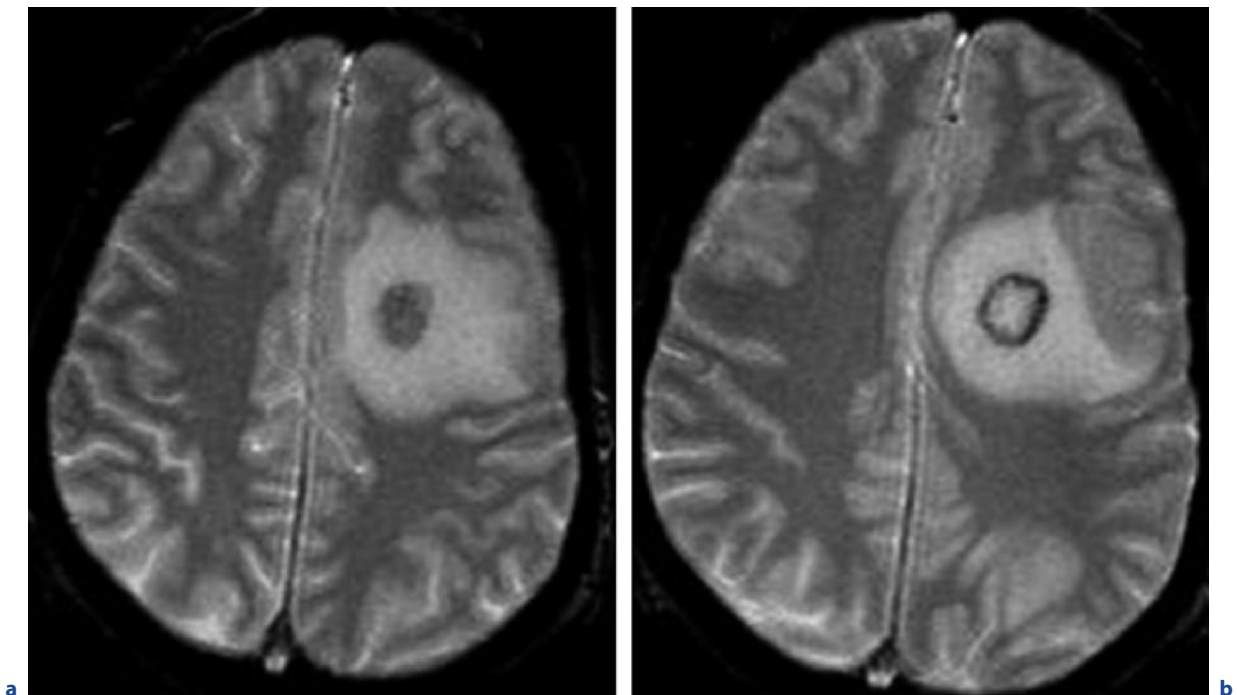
Development of an intraparenchymal aspergilloma over 6 months. a Initial examination. b Follow-up after 6 months. a,b Axial T2-weighted images. c,d see next page
